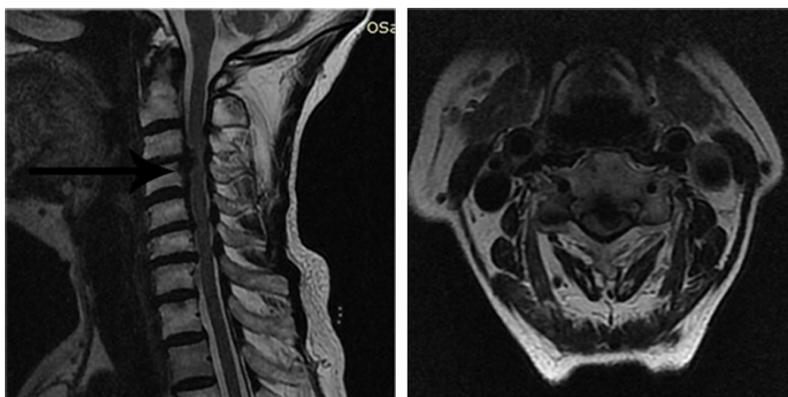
Left: Pre-operative cervical T2 -weighted MRI revealed C5-7 canal stenosis and high-intensity compression at C3-C4. Right: An axial image at C3-C4 (black arrowheads).
